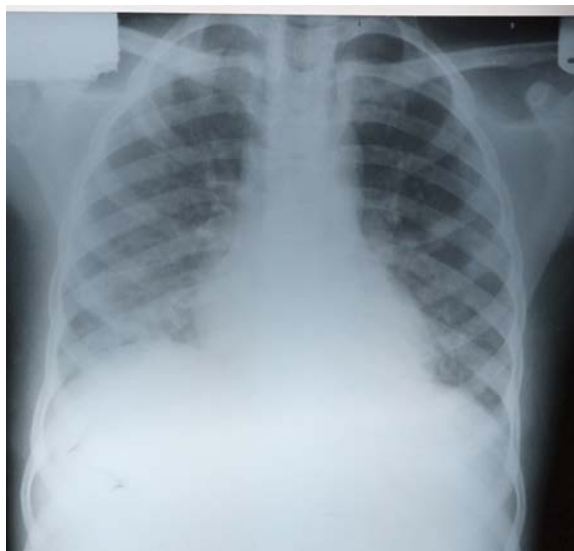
Chest X-ray showing bilateral patchy and reticulonodular opacities
